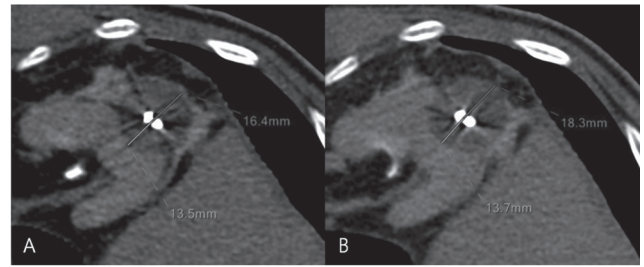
Reconstructed CT images from a 75 year-old man who underwent renal cryoablation using two cryoprobes. (A) The lateral radius (blue line) of a radiographic ice ball was longer than the medial radius (red line) during the first freezing (16.4 mm versus 13.5mm). (B) The lateral radius (blue line) of a radiographic ice ball was also longer than the medial radius (red line) during the second freezing (18.3 mm versus 13.7 mm).
